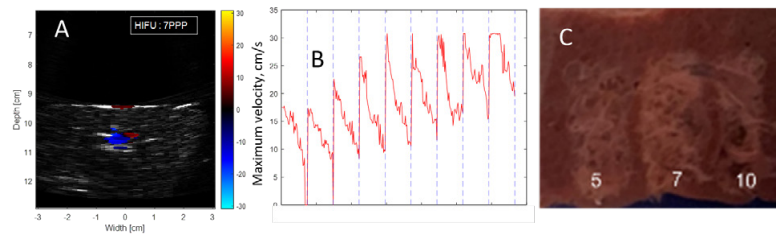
(A) Color Doppler image in ex vivo liver after the 7th BH pulse. (B) Residual bubble velocity after each BH pulse. (C) Rinsed volumetric BH lesions produced with 5, 7, and 10 pulses/focus.
